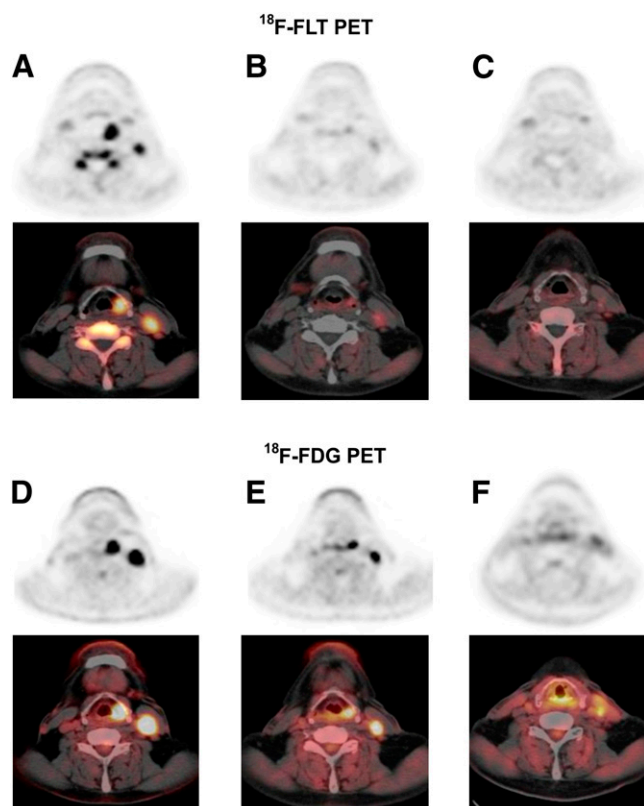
shows a typical case of hypopharyngeal cancer. The  $^{18}\text{F}$ -FLT accumulations in primary and metastatic lesions showed apparent decreases during RT, whereas  $^{18}\text{F}$ -FDG accumulations persisted.
